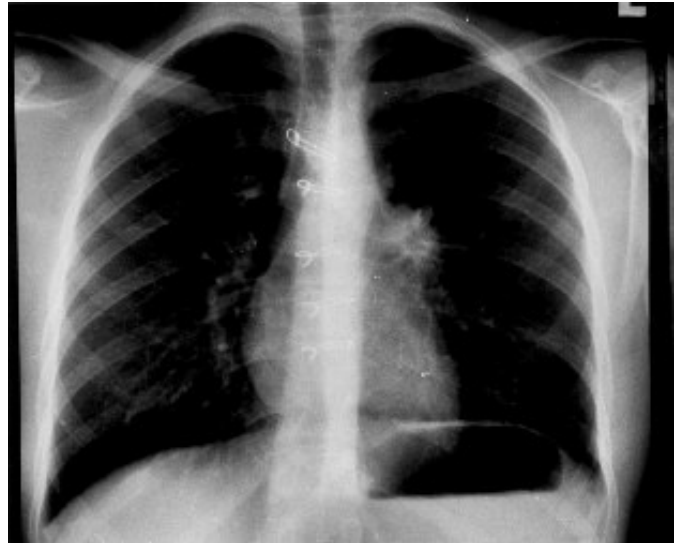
Roentgenogram of patient 2 shows marked regression of the neoplasm following chemotherapy.
